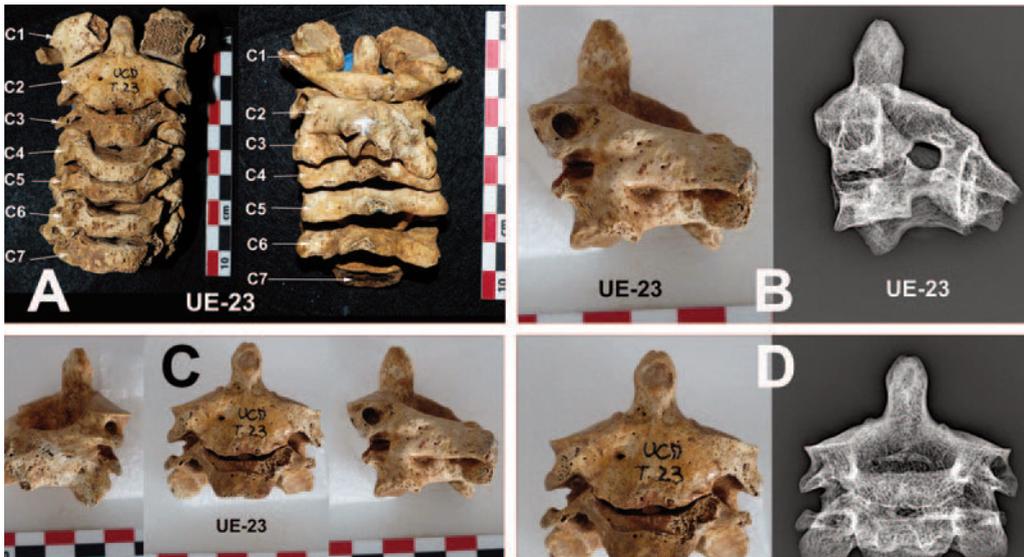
UE 123. (A) Set of cervical vertebrae. Anterior and posterior view. (B) Fusion between C2 and C3. Lateral view and Lat. X-rays. (C) Posterior, anterior and lateral view. (D) Anterior view and AP X-rays.
